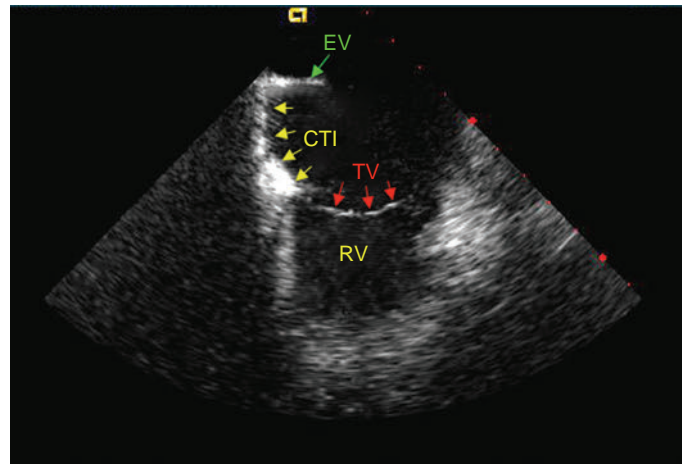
Intracardiac Echocardiographic (ICE) Image of the Cavotricuspid Isthmus (CTI). The CTI (yellow arrows) is shown between the eustachian valve (EV, green arrow) and the tricuspid valve (TV, red arrows). RV, Right ventricle.
